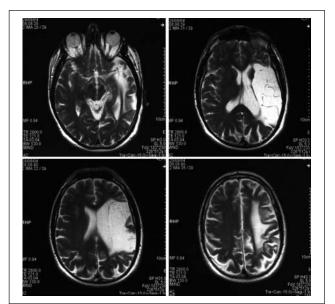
Brain magnetic resonance imaging performed 21 years after stroke. Lesion mapping showed involvement of Brodmann's areas 22, 21, 20, 37, 44, 6, 6s, 4, 40, 39, 3, 1, 2, 5, and 7 (MRIcron software, see http://www.mricro.com/mricron)
